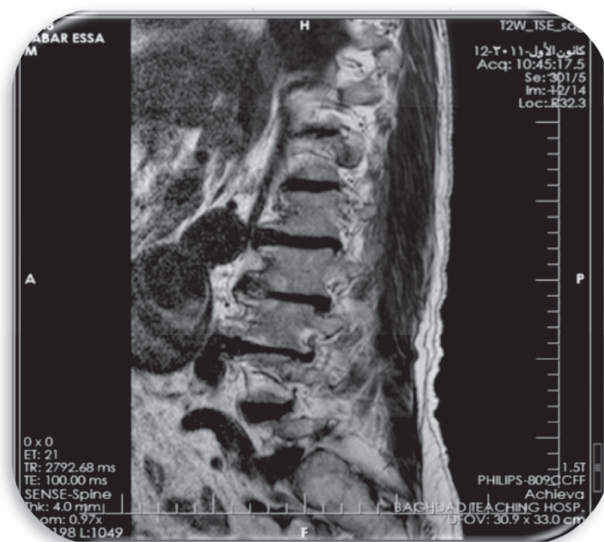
lumbar spinal MRI showed an aortic aneurysm measuring 5.5 cm in diameter.
